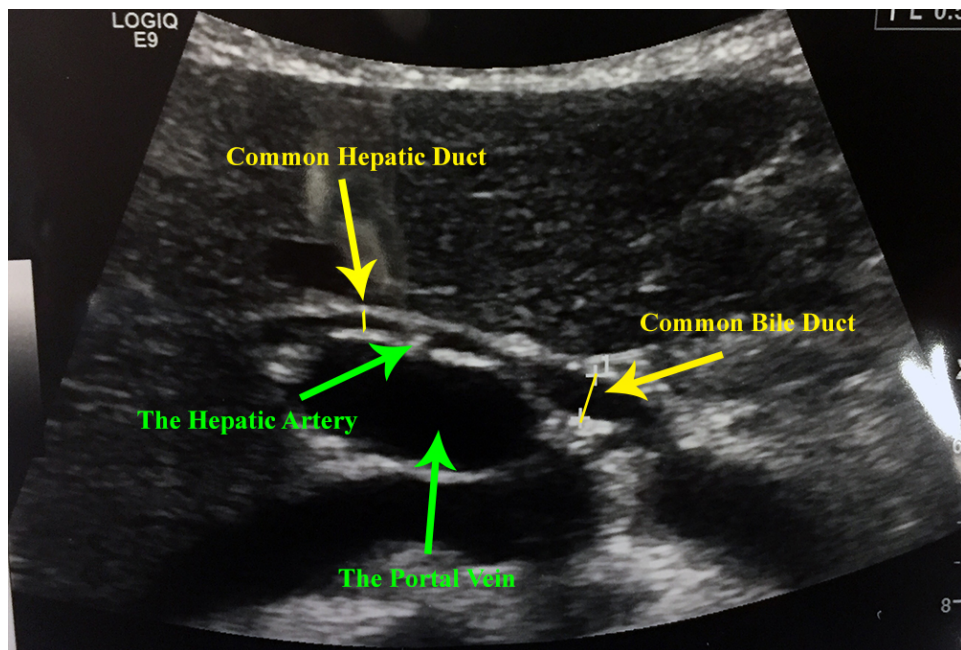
An ultrasound image showing the location of the CBD and CHD.
